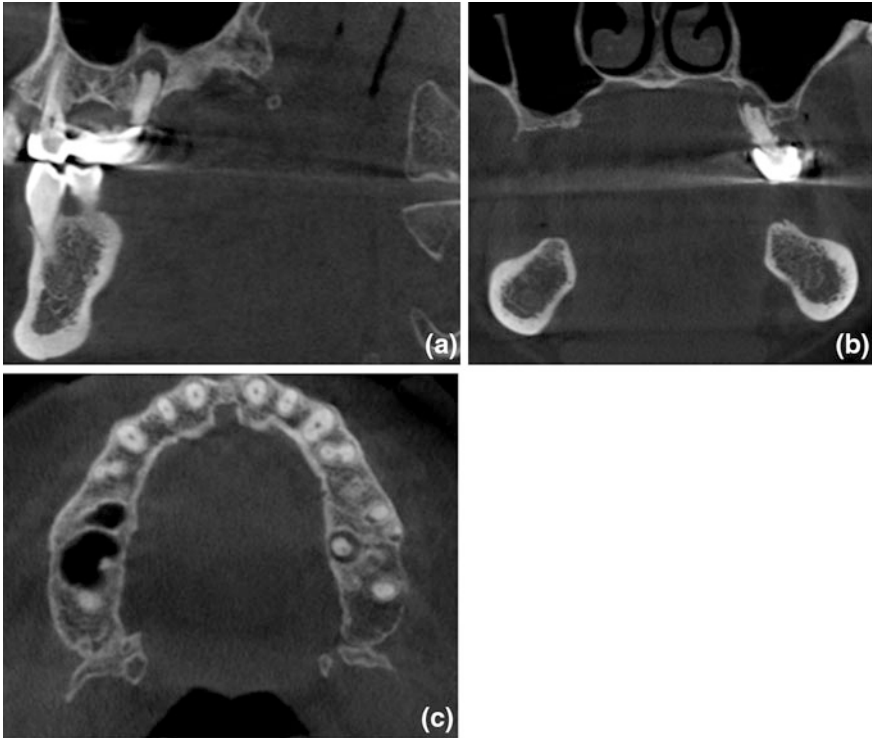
CBCT: coronal (a), sagittal (b), and axial (c) scans showing a radiolucent periradicular area dependent to the element 2.6
